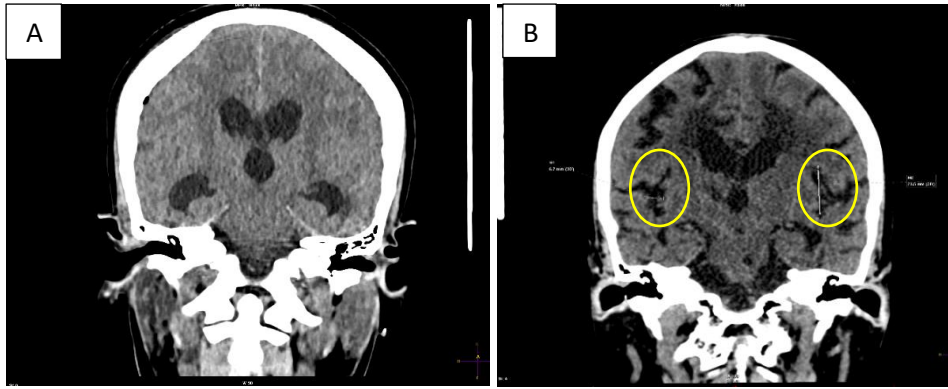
CT scans showing the Sylvian fissures. A) shows compressed Sylvian fissures, while B) shows dilated Sylvian fissures.
